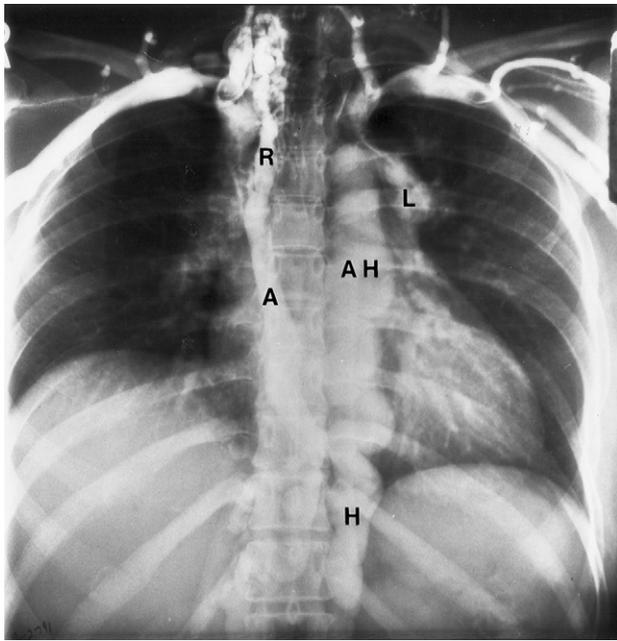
Fibrosing mediastinitis. Bedside AP chest radiograph accomplished during a bilateral upper extremity venogram demonstrates obstruction of the superior vena cava and both brachiocephalic veins. Note the enlarged collateral vessels at the base of the right neck filling the right superior intercostal vein (R), and the markedly enlarged left superior intercostal vein (L), azygous (A), hemiazygous (H), and accessory hemiazygous (AH) veins.
